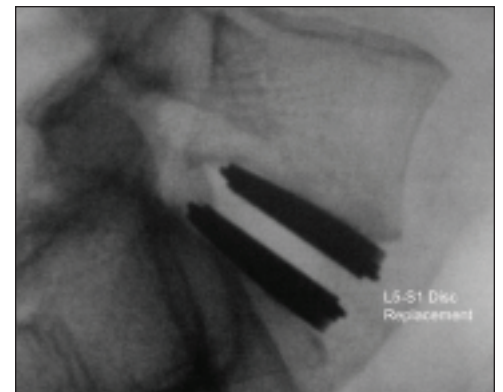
A postoperative lateral radiograph of a patient with an L5-S1 disc replacement
